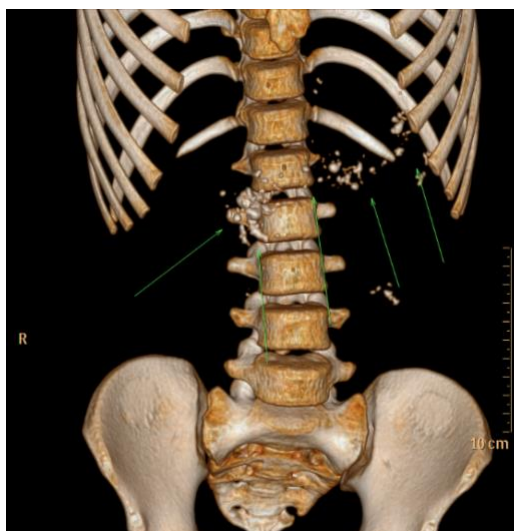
Three-dimensional visualization of abdominal CT scan showing multiple stones (green arrows) in the pancreas.
